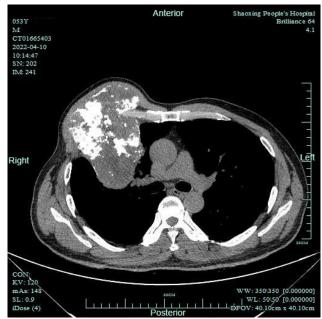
The Contrast-enhanced chest CT shows the tumor in the horizontal plane.
